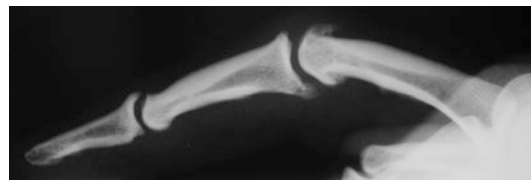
Radiographic finding of osteoarthritis in a long-time climber (over 35 years of climbing). Surprisingly, the climber is almost pain-free!
